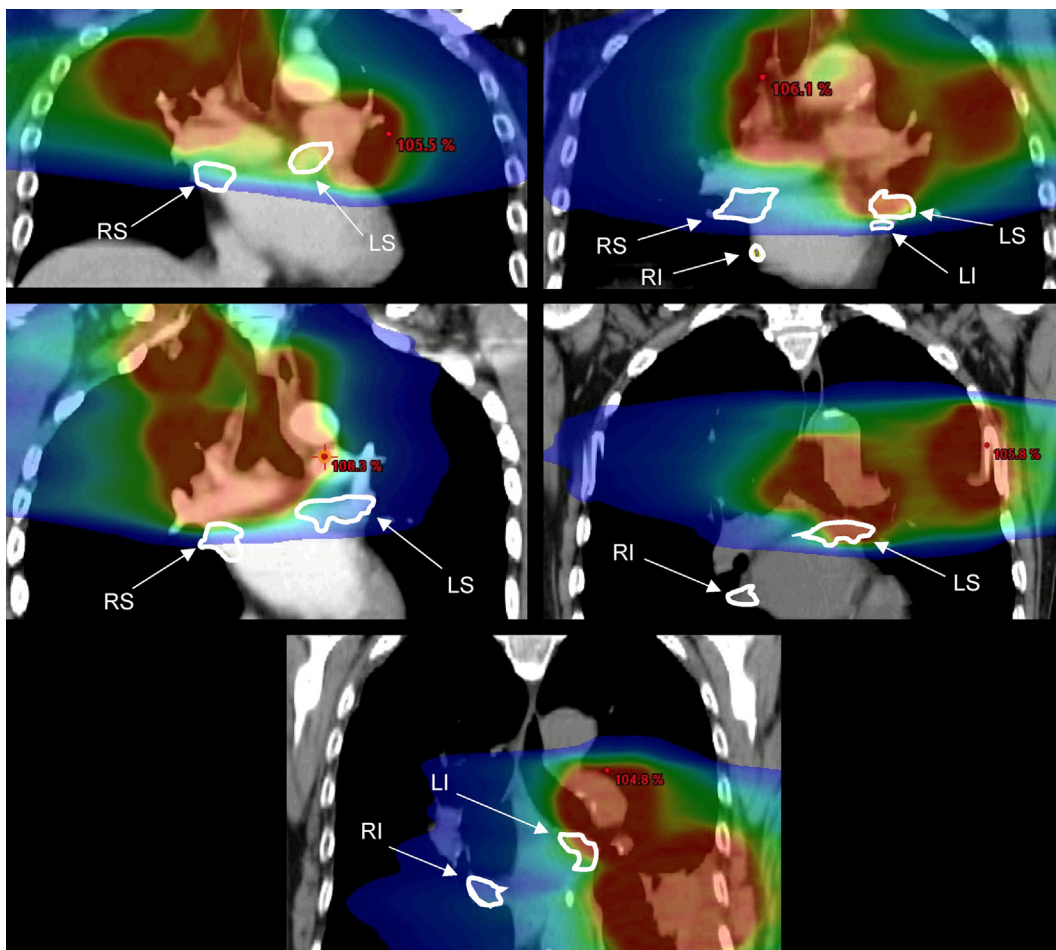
Representative coronal average image projection slices from the four-dimensional computed tomography radiotherapy plans of the five included patients including pulmonary vein delineations (highlighted with white arrows) and the radiation dose distribution overlaid (RS = right superior pulmonary vein; RI = right inferior pulmonary vein; LS = left superior pulmonary vein; LI = left inferior pulmonary vein).
